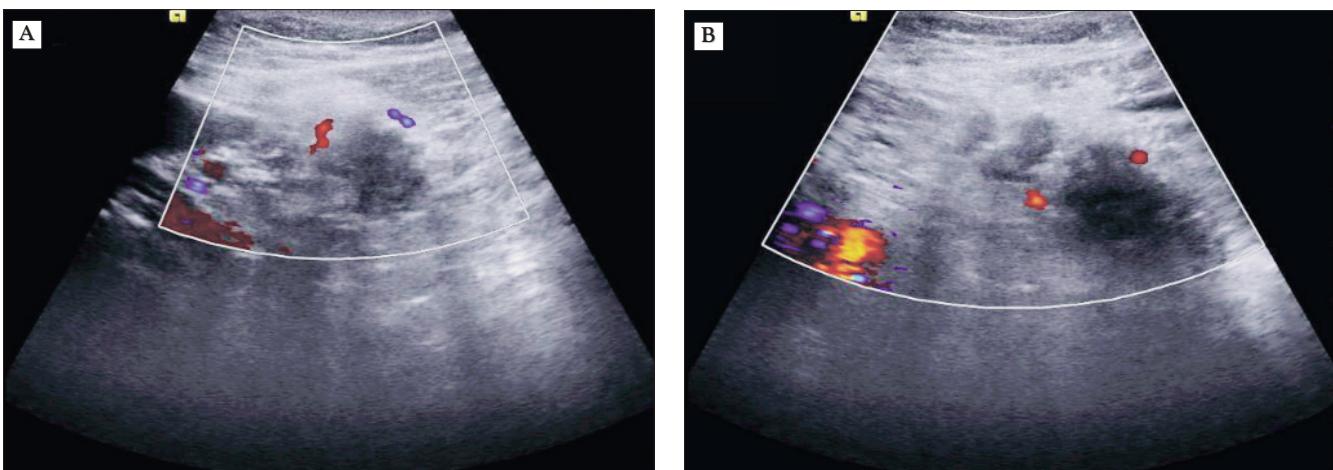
Doppler ultrasound with contrast agent SONO VUE – personal collection
